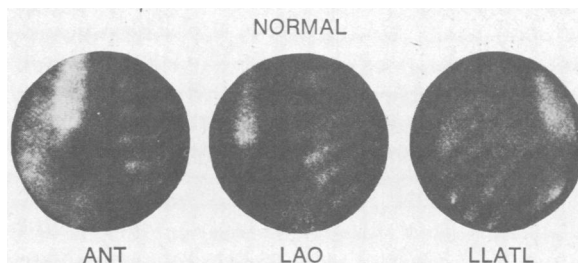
Normal TcPYP scintigram. Shown are the normal scintigrams in a patient with chest pain but without acute infarction. (From Prasquier R, et al: *Circulation* 55:61-66, 1977.⁵¹ With permission of the authors and the American Heart Association.)
